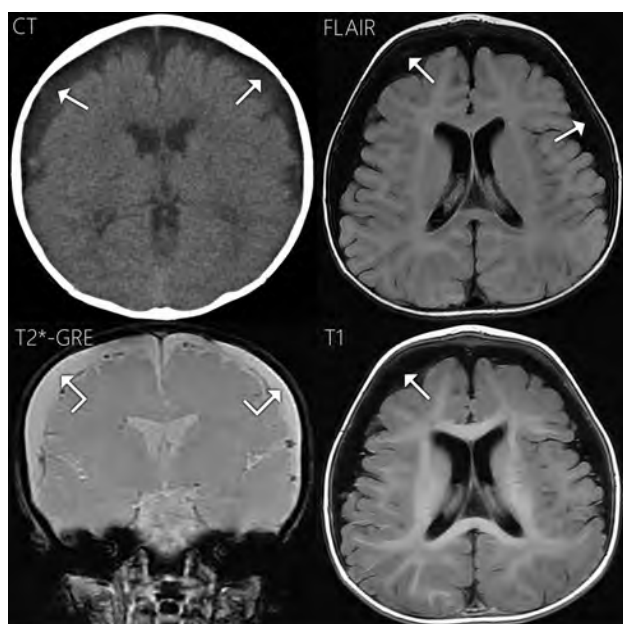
Case 3. Axial NCCT demonstrates bilateral subdural collections slightly hyperattenuating to CSF (white arrows). On FLAIR and T1WI, the subdural fluid is nearly isointense to CSF with subtle areas of hyperintensity reflecting CSF flow artifacts (white arrows). On T2*-GRE, the subdural fluid is isointense to CSF (angled white arrows) with no blooming or susceptibility effects along the dural surface. The multiple tubular hypointense structures on T2*-GRE are cortical veins.
